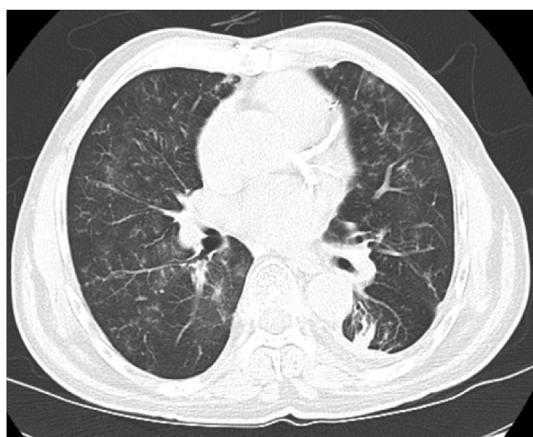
High resolution chest tomography (HRCT) images of patient's lungs showing diffuse small airway thickening with cylindrical bronchiectasis. Diffuse bilateral fine ground glass opacities and diffuse tree-in-bud nodularity.
